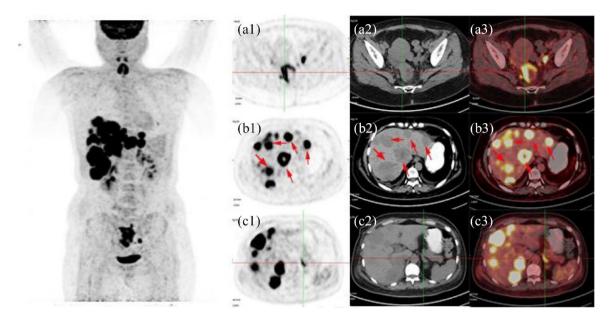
Results of ¹⁸F-FDG positron emission tomography-computed tomography. (a1–a3) Rectal tumor. (b1–b3) Liver metastases. (c1–c3) Left adrenal gland with metastasis. See red arrows and intersections.
